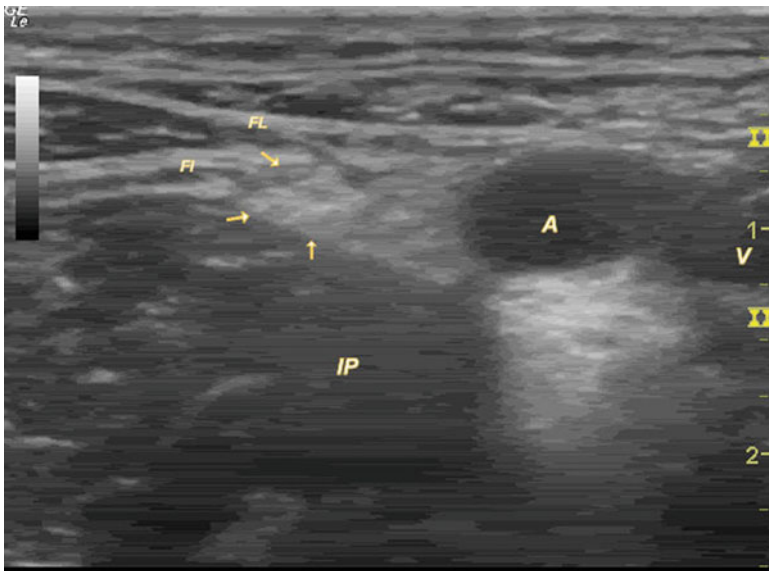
Ultrasonographic appearance of the femoral nerve. The femoral nerve (*arrows*) is observed superior to the iliopsoas muscle (*IP*) and lateral to the femoral artery (*A*) and femoral vein (*V*). It is encased by the fascia iliaca (*FI*) and bounded superiorly by the fascia lata (*FL*)
